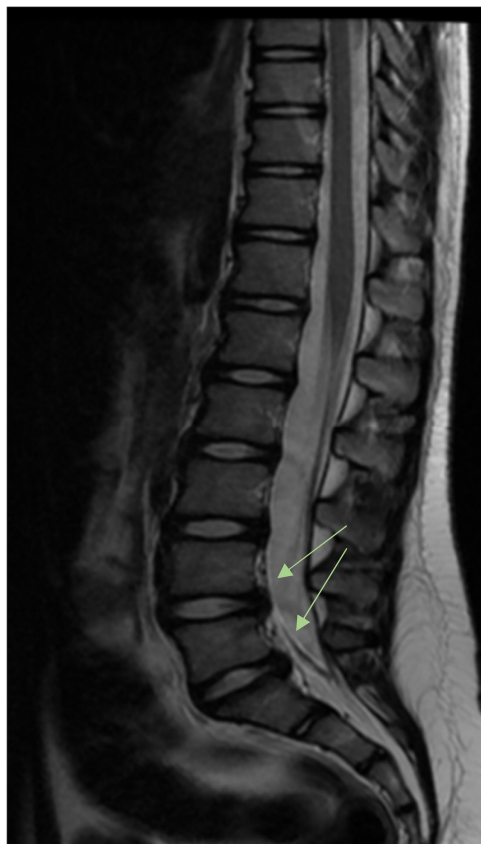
Second MRI of the lumbar spine T2 SAG
